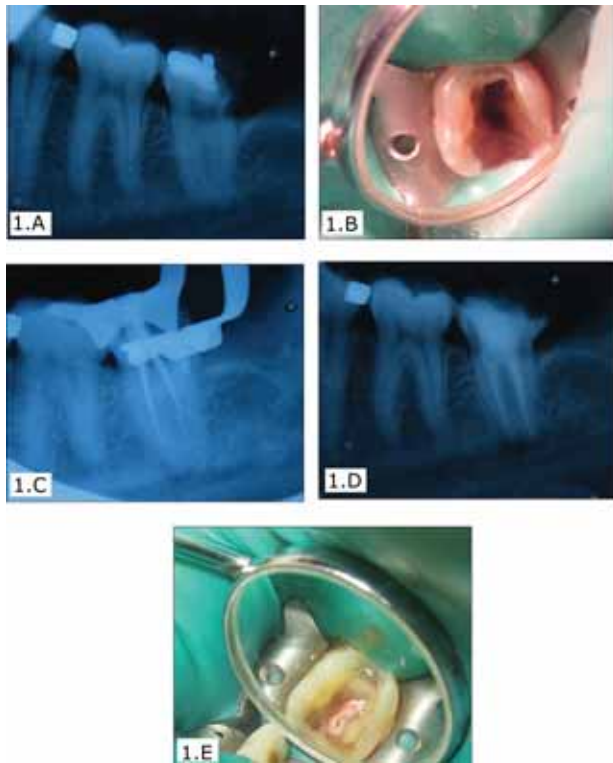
Preoperative radiograph of right mandibular second molar
